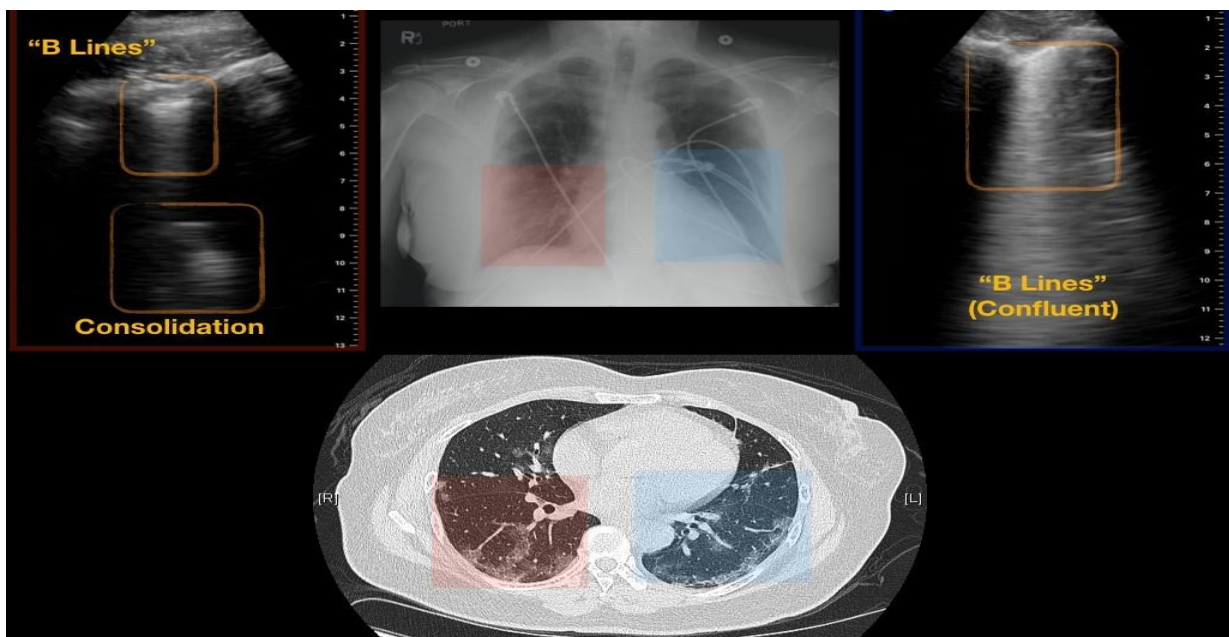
69year old male COVID-19 patient. Day 12 of symptom onset. Lung ultrasound shows; “A-lines”, confluent “B-lines”, “waterfall sign”. CXR shows peripheral opacification. CT chest shows ground-glass opacities and early consolidation.
